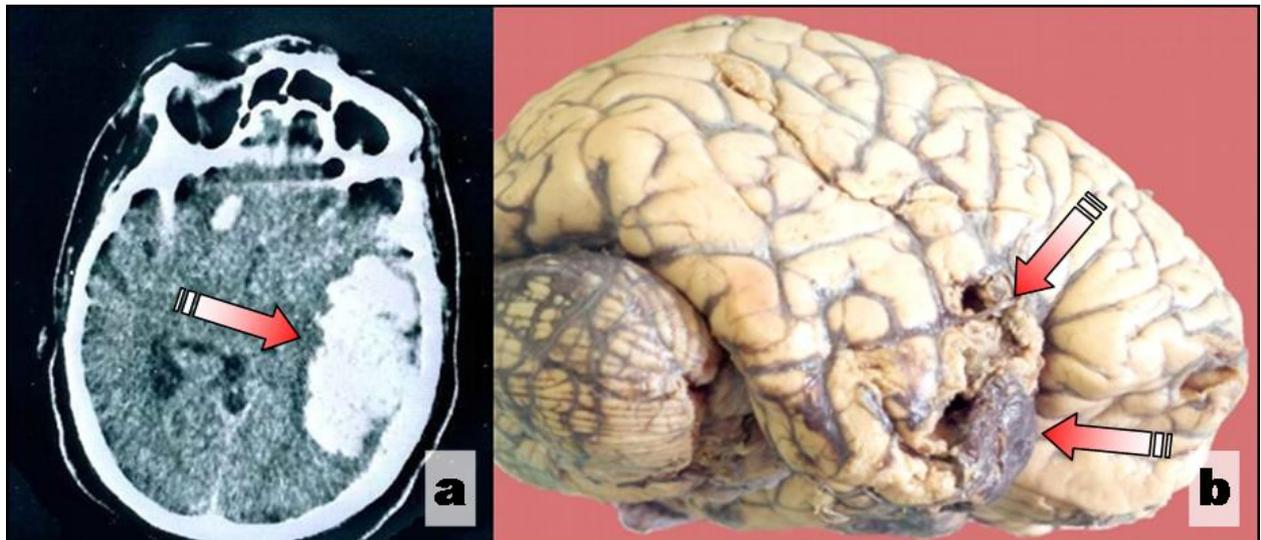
Right side extended temporal-parietal hematoma: (a) CT aspect; (b) Necropsy gross aspect.
